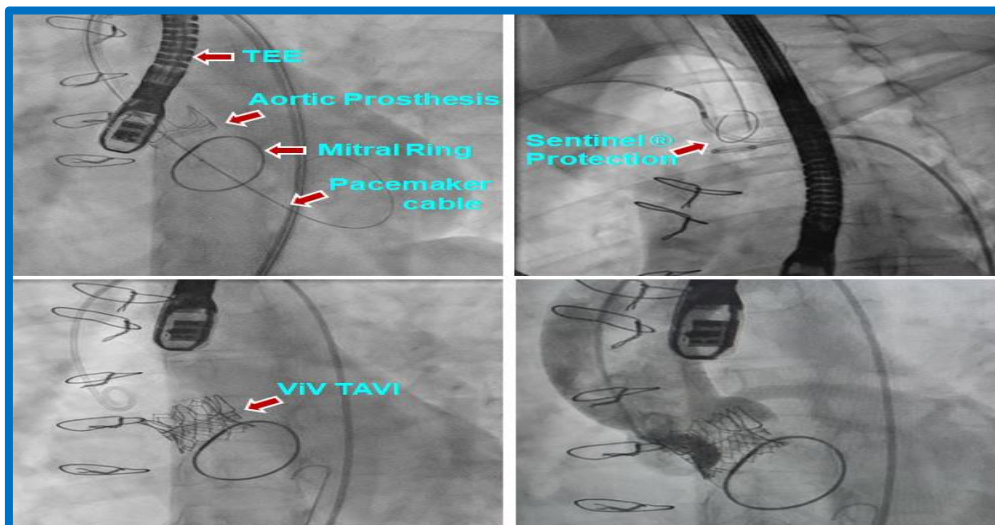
Radioscopic images of the Valve in Valve (ViV) procedure, Transcatheter Aortic Valve Implant (TAVI). Monitoring with transesophageal echo-Doppler (TEE). Embolization protection with the Sentinel® system
